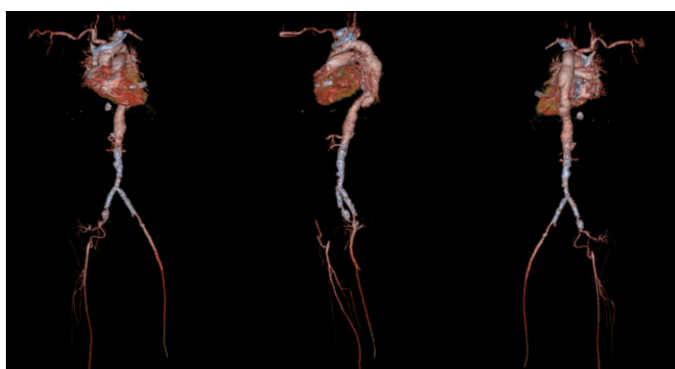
CT aortogram showing fusiform aneurysm of the descending thoracic aorta with Stanford type B dissection. Additional findings include aneurysms of the left renal and right internal iliac arteries, significant right renal artery stenosis and complete occlusion of the right external iliac artery with collateral supply from the right internal mammary artery.
